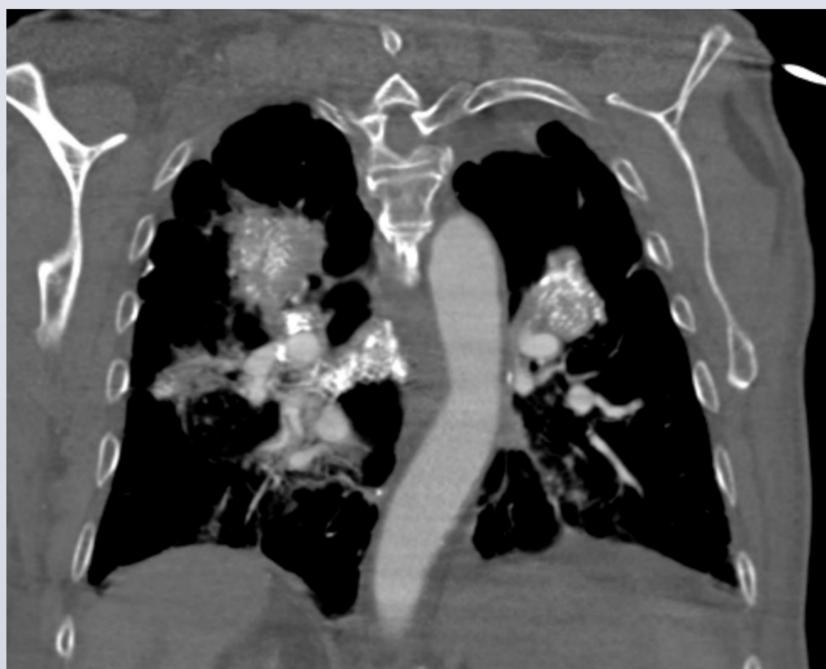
CT Chest demonstrates bilateral upper lobe large conglomerate masses with stippled calcifications and radiating strands.
